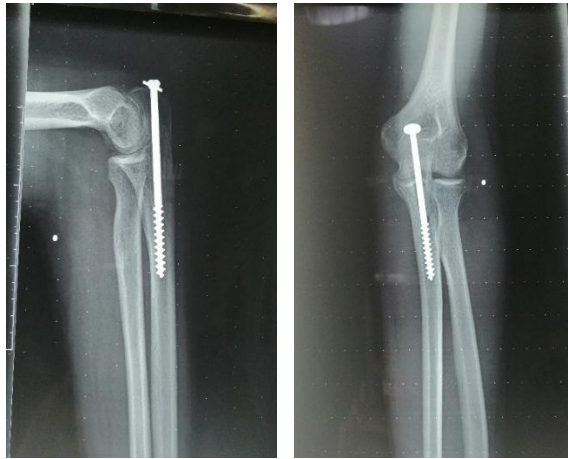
6 weeks follow up x-rays showing union.
